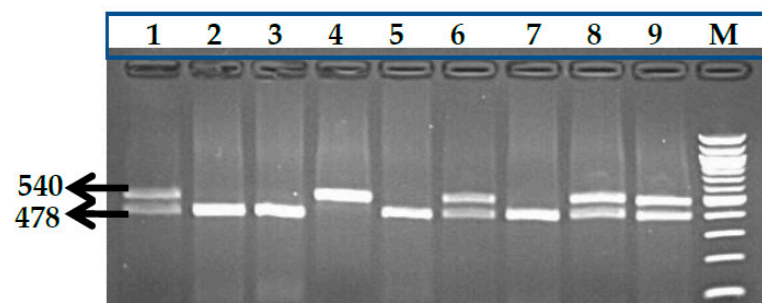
Gel pictures showing the genotypes of BCL11A gene, rs11886868 (C>T) polymorphisms. Lane 4: CC (wild type), Lanes 1, 6, 8 and 9: CT (heterozygous), Lanes 2, 3, 5 and 7: TT (homozygous mutant), M: 100 bp DNA marker.
